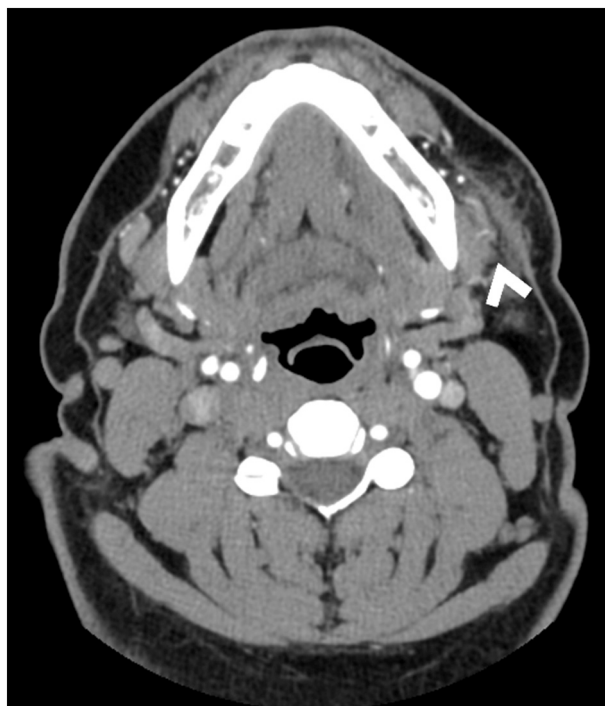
Axial CT angiography image of the head and neck at the site of injury. No major arterial injury or focus of contrast extravasation was seen. It was noted that the left facial vein (arrowhead “<”) was directly deep to the area of injury and demonstrated focal vessel irregularity and surrounding fat stranding.
